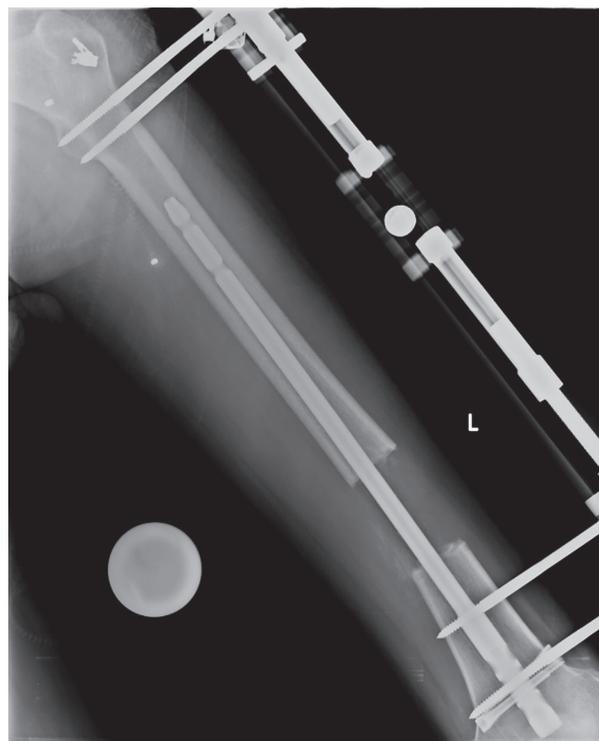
The contralateral x-ray of the same patient during the lengthening period (left femur).
